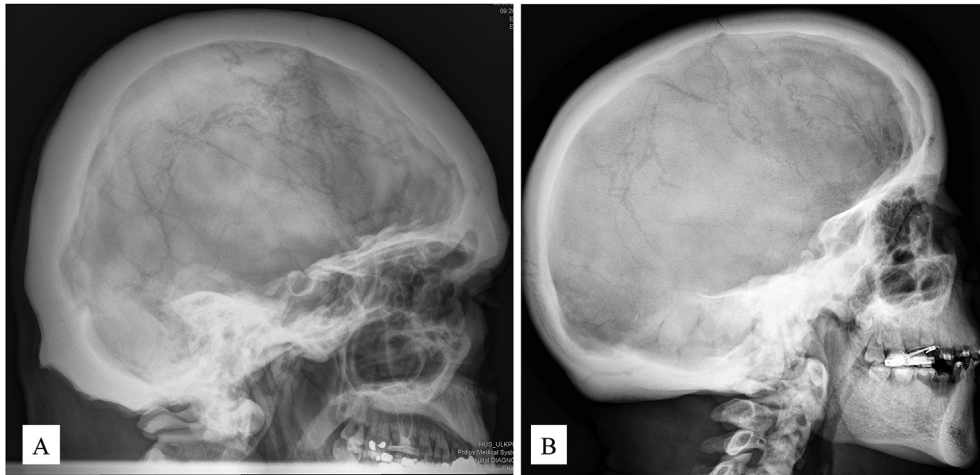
Cranial radiographs from two patients with different genetic defects in WNT pathway components. A) Cranial X-ray of a 53-year-old male with high bone mass due to a heterozygous missense mutation p.N198Y in *LRP5* showing cranial hyperostosis with thickened skull bones, underpneumatized paranasal sinuses and prominent jaw. B) Cranial X-ray of a 17-year-old female with OPCS due to novel X-chromosomal heterozygous frameshift deletion p.E219Rfs*63 in *AMER1*. Figure shows enlarged head circumference (+6 SD), dense cranial bones and prominent jaw.
